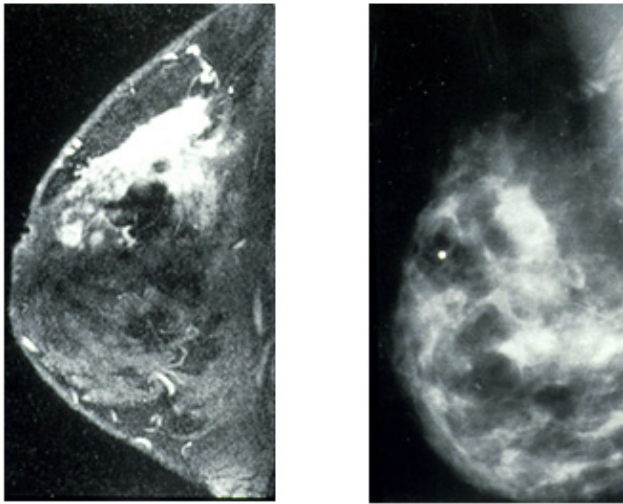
Mamo right image and the left image is an MRI image.
